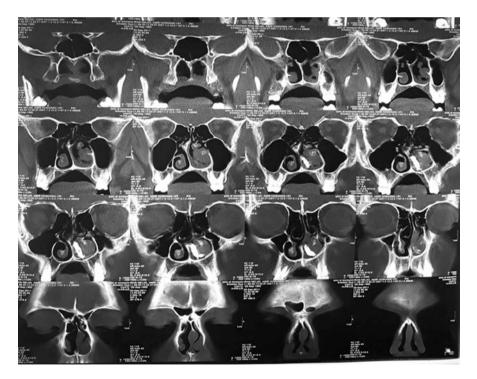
Paranasal sinus computed tomography scan of a patient with copious nasal secretions. Foreign body with radiodense surrounding rhinolithiasis can be seen in right maxillary sinus in cuts 7 to 11
